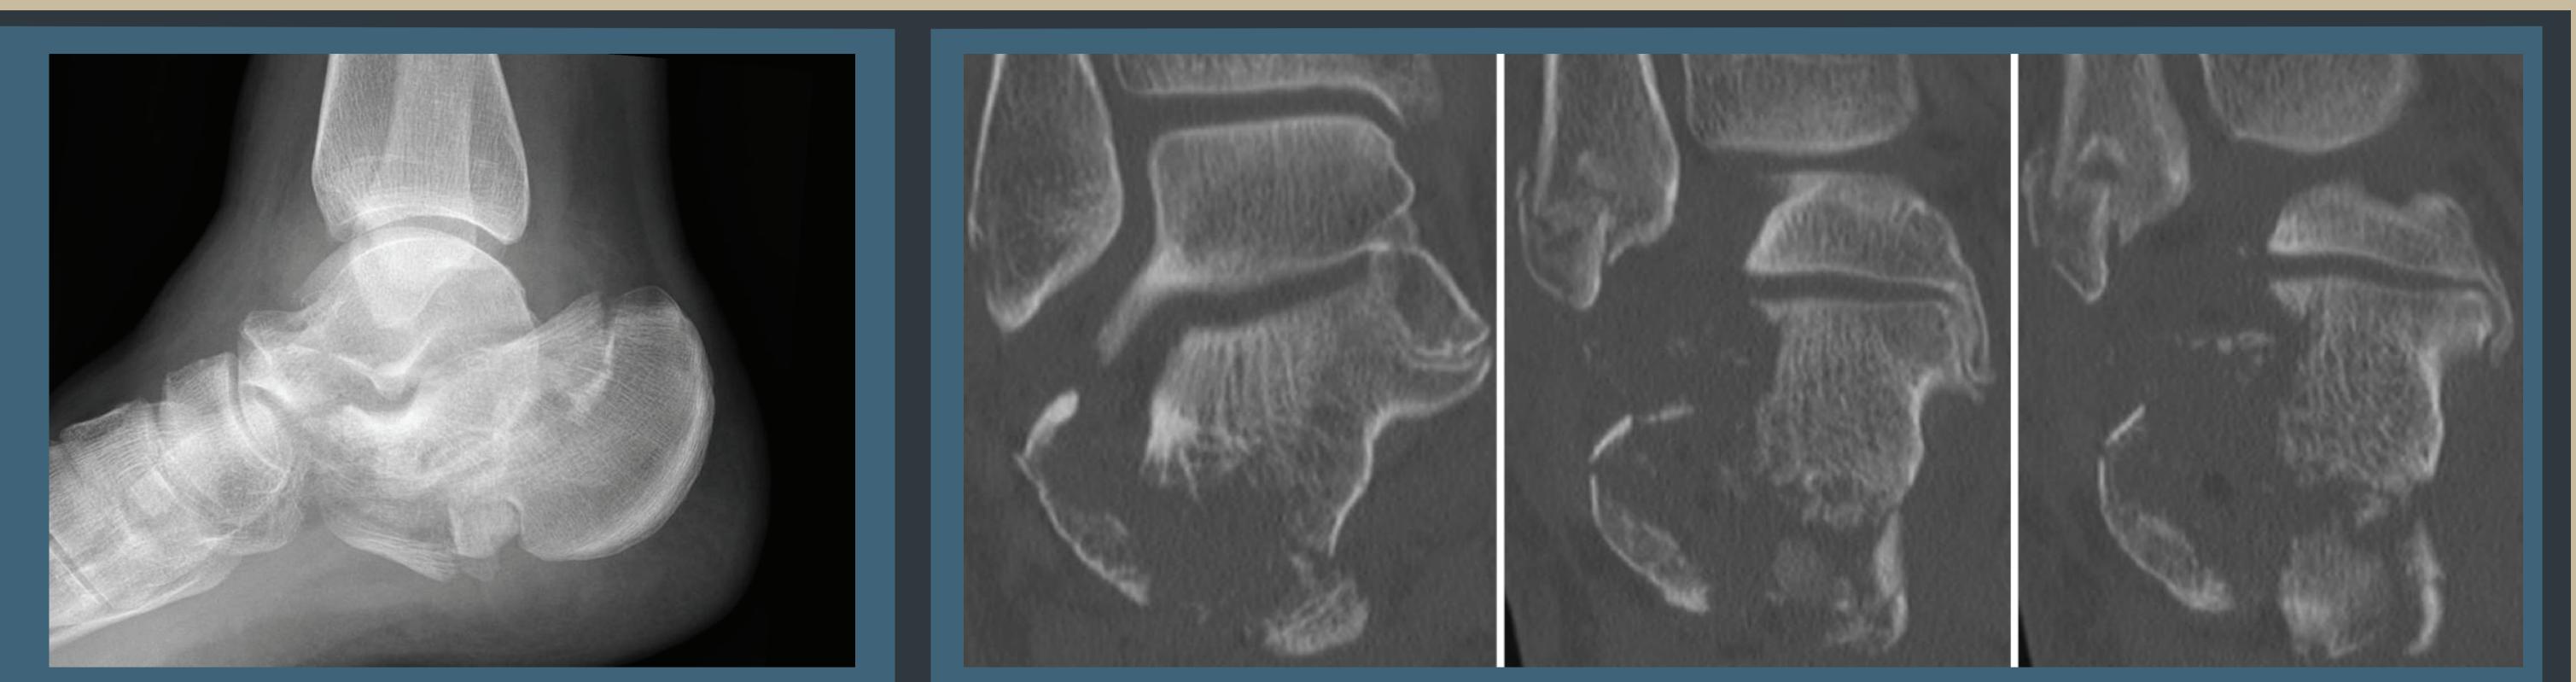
Pre-operative radiographs showing calcaneal fracture
